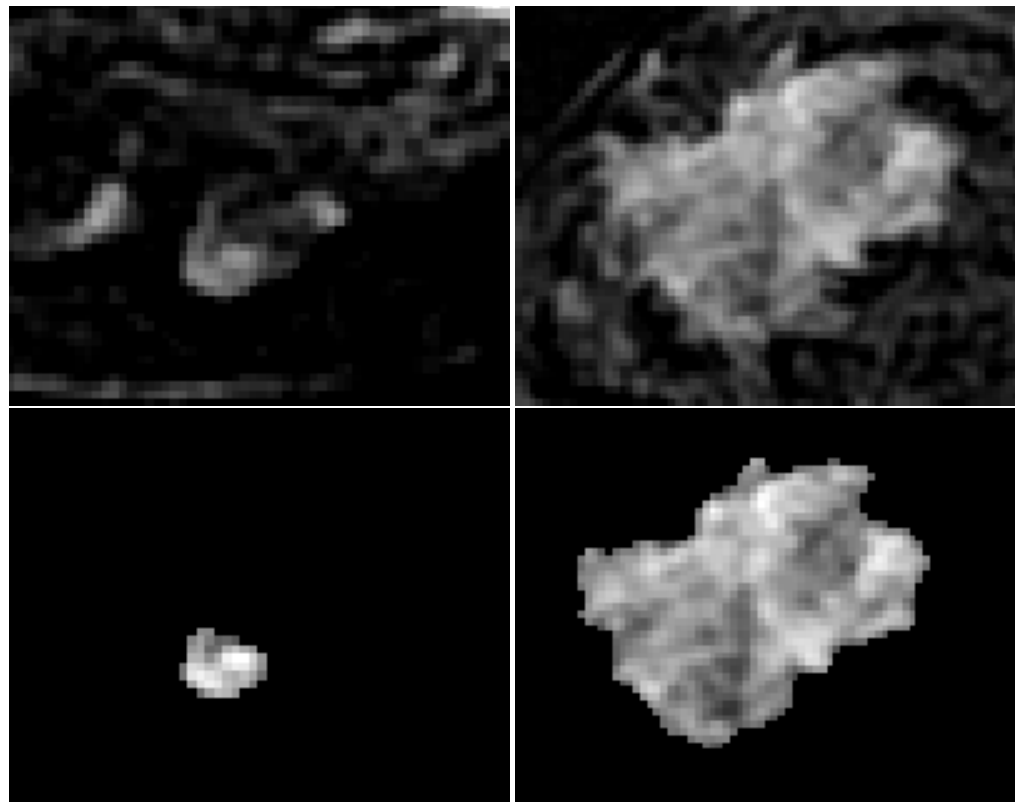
Two examples of segmentation obtained by sFCM: (1st row) the original DCE-MRI images; (2nd row) the corresponding segmentation. Compared to the images shown in Figures 4 and 6, a $2\times$ zoom factor was used, that allows us to better appreciate the lesion non-homogeneity that only clustering approaches can properly manage, thus maximizing the final result accuracy.
